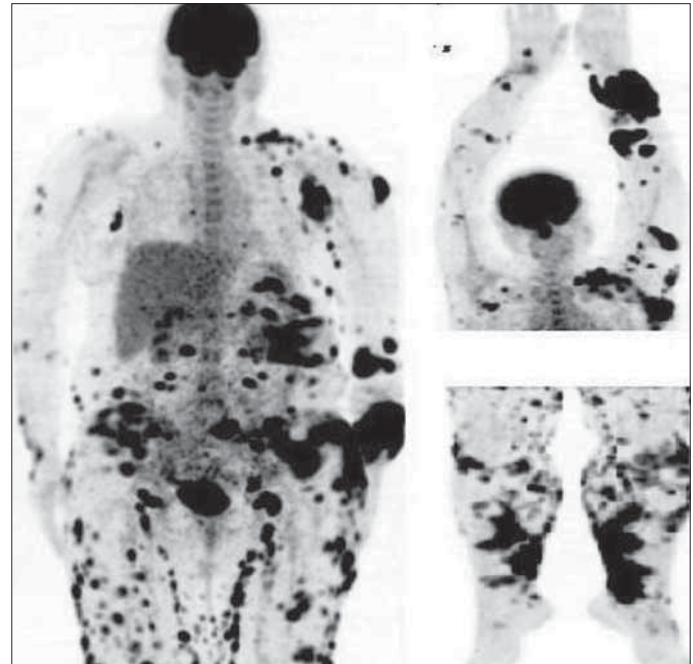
Appearance of multiple abnormal uptake on FDG-PET
